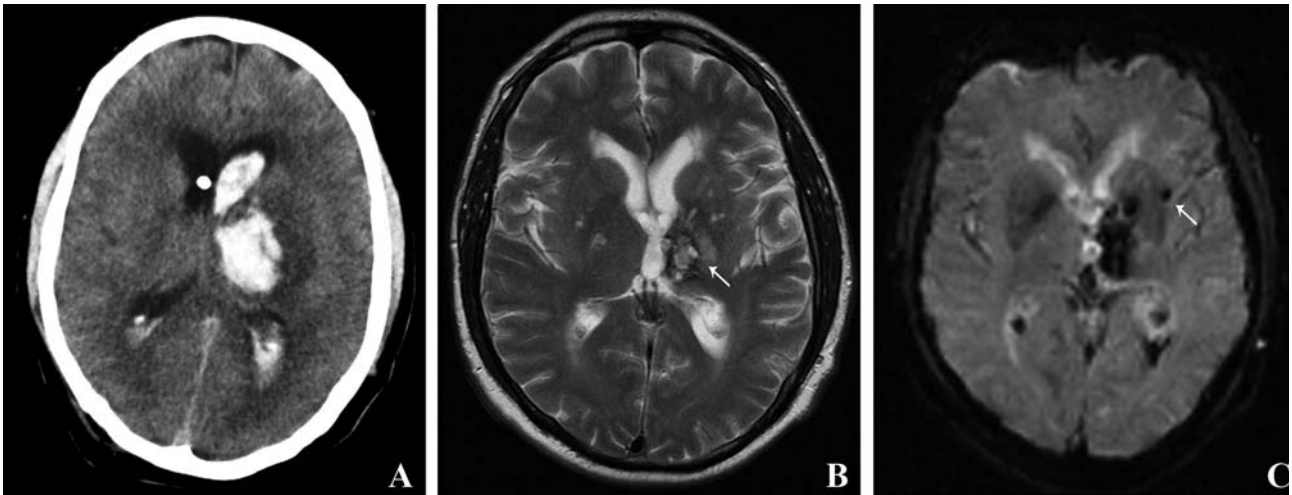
A : Computed tomography of the brain shortly after the first bleeding shows an acute haemorrhage in the left putamen and capsula interna with surrounding edema ; B : Follow-up MRI one year after the first bleeding. T2 weighted image shows the sequellae of the intracerebral haemorrhage ; C : Hypointense lesion compatible with a microhaemorrhage (arrow) as seen on perfusion weighted imaging.
